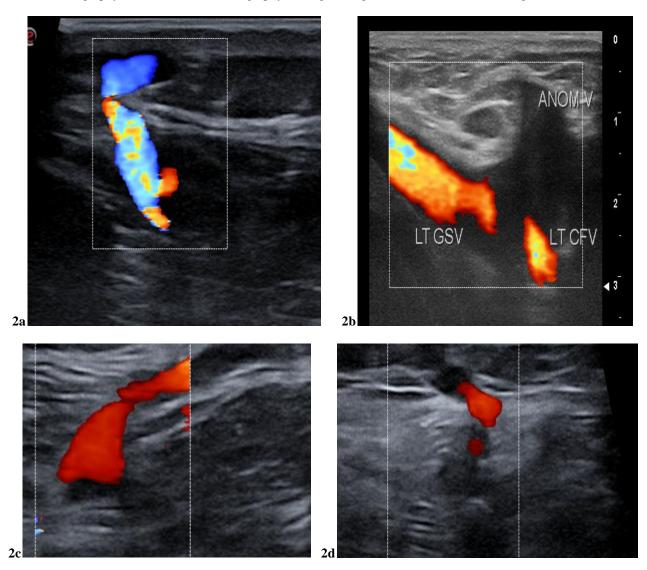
Color doppler findings include normal deep venous system noted on left side
